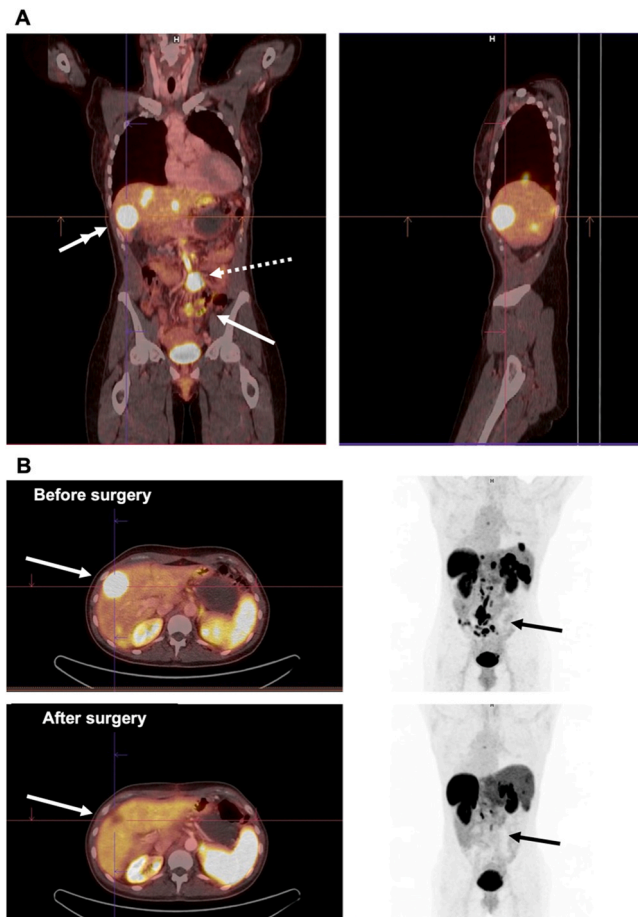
Patient with small bowel NET and liver metastasis. Legend: A. Gallium-DOTATOC PET-CT showing small bowel tumor (arrow) with mesenteric metastasis (pointed line arrow) and liver metastasis (double arrow). B. Patient underwent debulking surgery of the small bowel with lymphadenectomy, mesenteric tumor debulking and liver resection. Images are before (top) and after (bottom) surgery.
